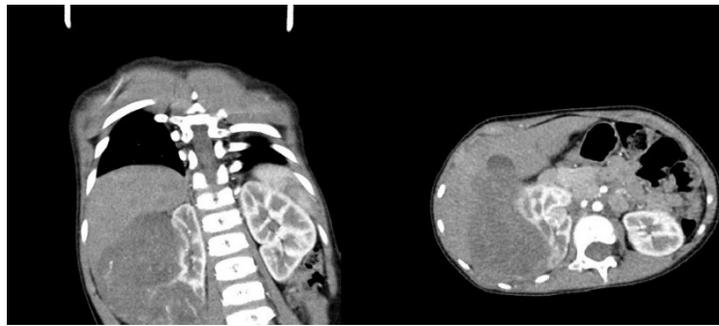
Nephroblastoma, CT images
